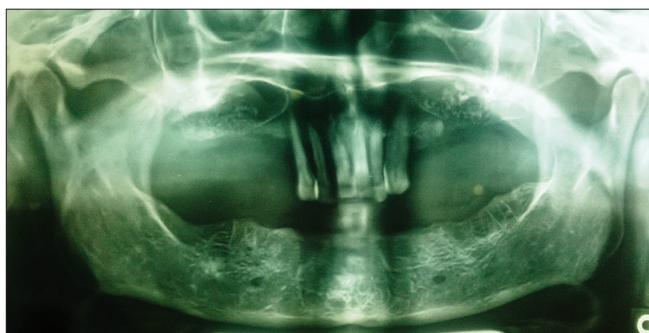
Three months postoperative orthopantomography showing adequate bone height
